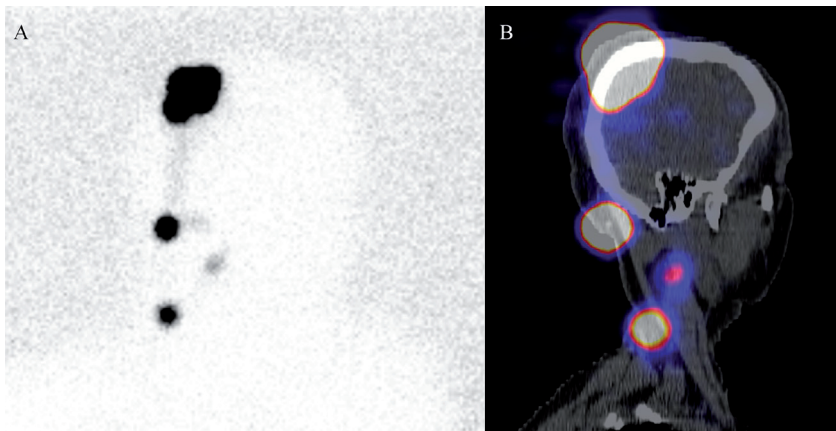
Lymphoscintigraphy (A) and SPECT/CT (B) images of a patient with a primary melanoma on the scalp and lymph nodes in the neck.
